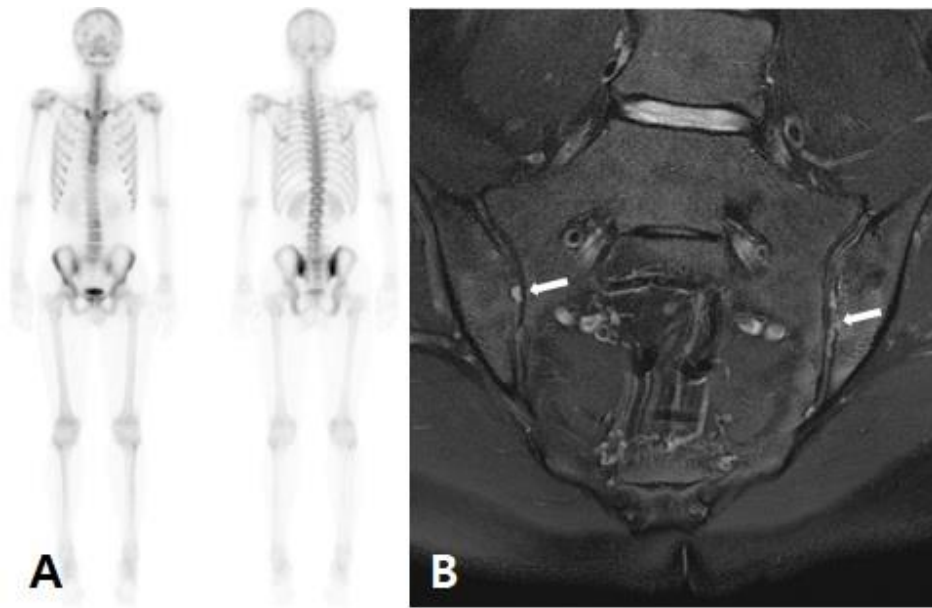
Whole body bone scan and pelvic MRI of a 20-year-old male patient with ankylosing spondylitis. (A) Whole body bone scan exhibiting increased radioisotope uptake at both sacroiliac joints. (B) Coronal T2 fat suppression MRI of pelvis showing mild bone erosion and bone marrow edematous changes at both sacroiliac joints (white arrows)
